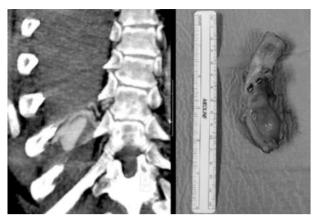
Aneurysm of the intercostal artery in a patient with neurofibromatosis type 1 (NF1). Computed tomography (left) and surgical piece (right).
